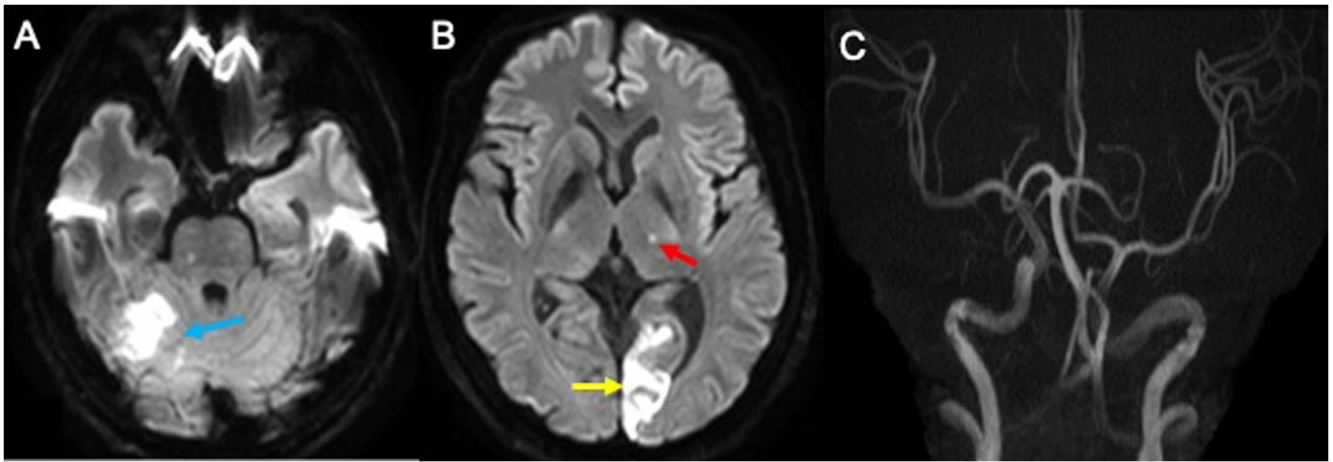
(A, B) MRI diffusion weighted images showed multiple high-intensity areas at left posterior lobe(yellow arrow), right cerebellum(blue arrow) and left thalamus(red arrow) of the left posterior cerebral artery (PCA) and the right superior cerebellar artery (SCA) territory (C) Magnetic resonance angiography (MRA) showing no significant stenosis of the intracranial main artery.
